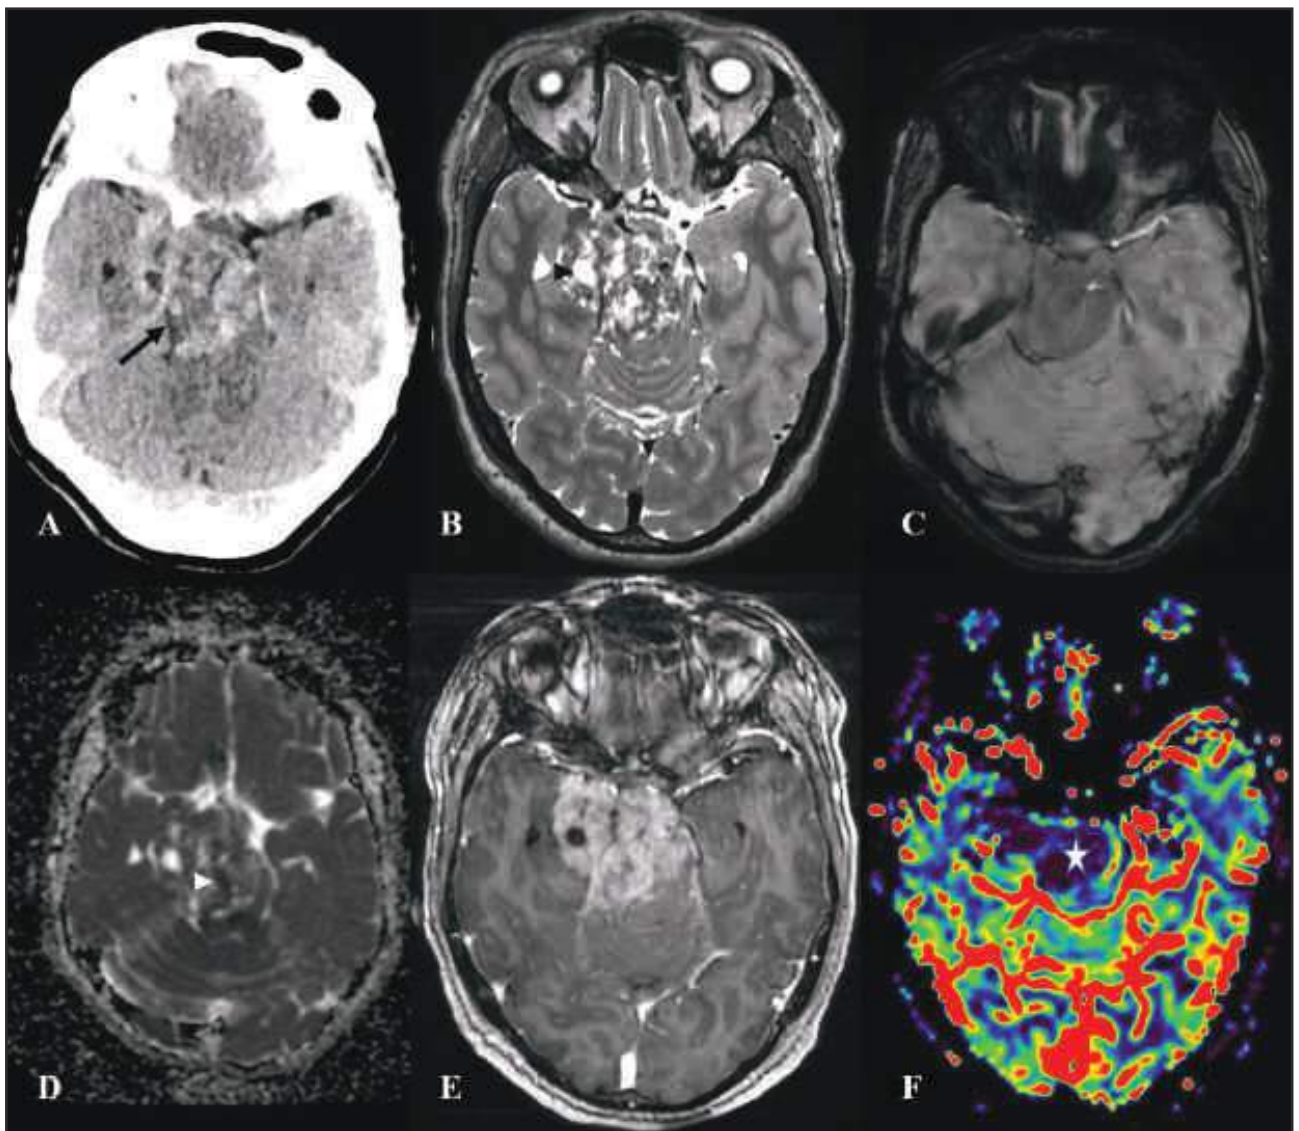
The axial non contrast CT head image (A) shows an ill–defined hyperattenuating extra–axial mass epicentered at the right prepontine and right cerebellopontine angle cistern extending to right middle cranial fossa (black arrow). The axial T2W MR brain (B) shows the lesion to be heterogeneous in signal intensity with internal cysts (black arrowhead) and epicentered at right petroclivoid ligament. The susceptibility weighted imaging (C) didn't show any obvious haemorrhage or calcification within. The ADC map of diffusion images (D) shows few foci of restricted within (white arrowhead). The post contrast scan reveals heterogeneous moderate enhancement (E) with areas of internal necrosis. The cerebral blood volume perfusion image (F) shows the lesion to be hypoperfused (asterix).
